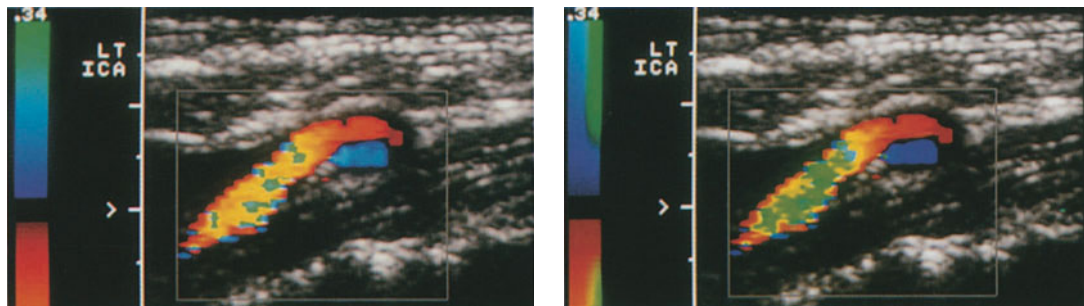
Longitudinal sonogram of high-grade ICA stenosis with post-stenotic color mosaic pattern with a mixture of red and blue with different degrees of color saturation, indicating post-stenotic turbulence
